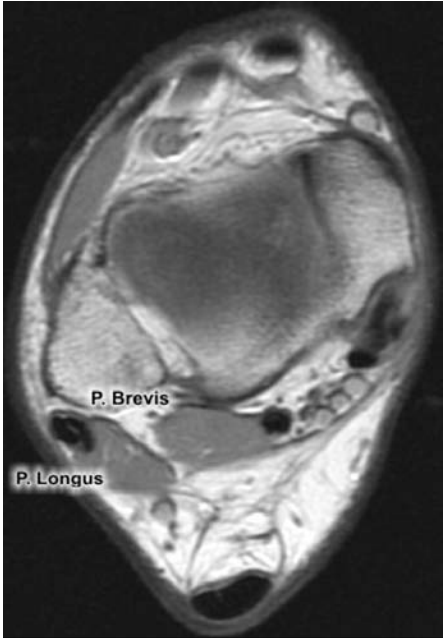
Axial T1-weighted MRI.
